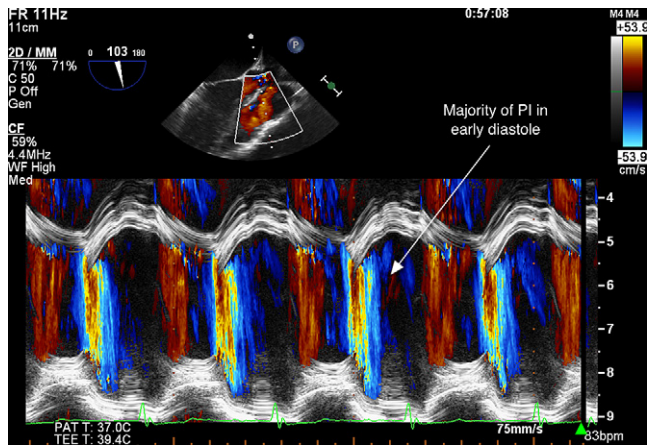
Color Doppler M-mode on transesophageal echocardiography reveals that the majority of PI occurs during early diastole.
